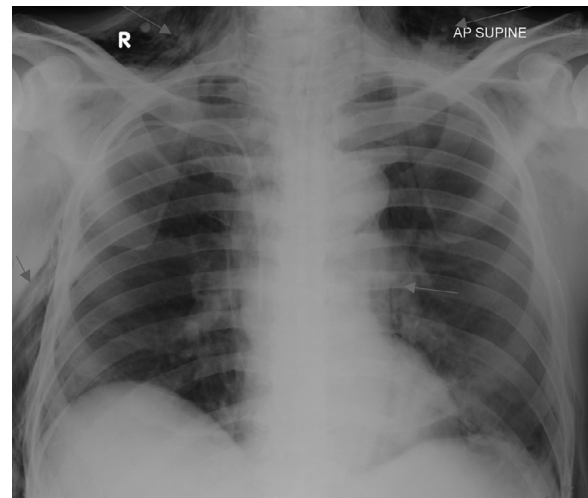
Chest X-Ray on day 10, showed a massive emphysema subcutis in bilateral supraclavicular & lateral chest walls (blue arrow), also a fine linear lucent area in the mediastinum, supporting pneumomediastinum (red arrow) (color version of figure is available online.)
